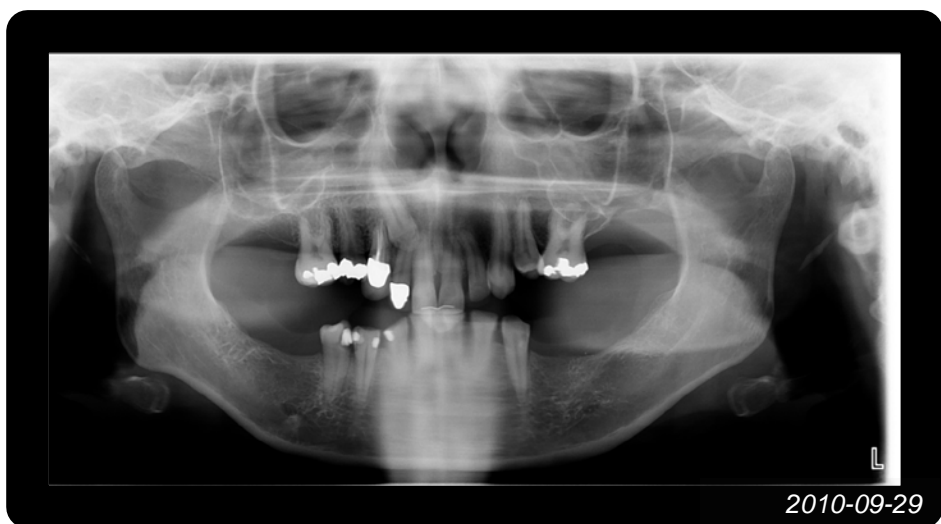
Radiopaque material consistent with intermediate restorative material (IRM) is seen partially in place in cavity, surrounded by a radiolucent area in the dentin which radiographically seems to extend into the pulp. It was not possible to conduct a periapical radiograph without a large degree of tissue damage. (Courtesy; Department of Maxillofacial radiology, UiO)
